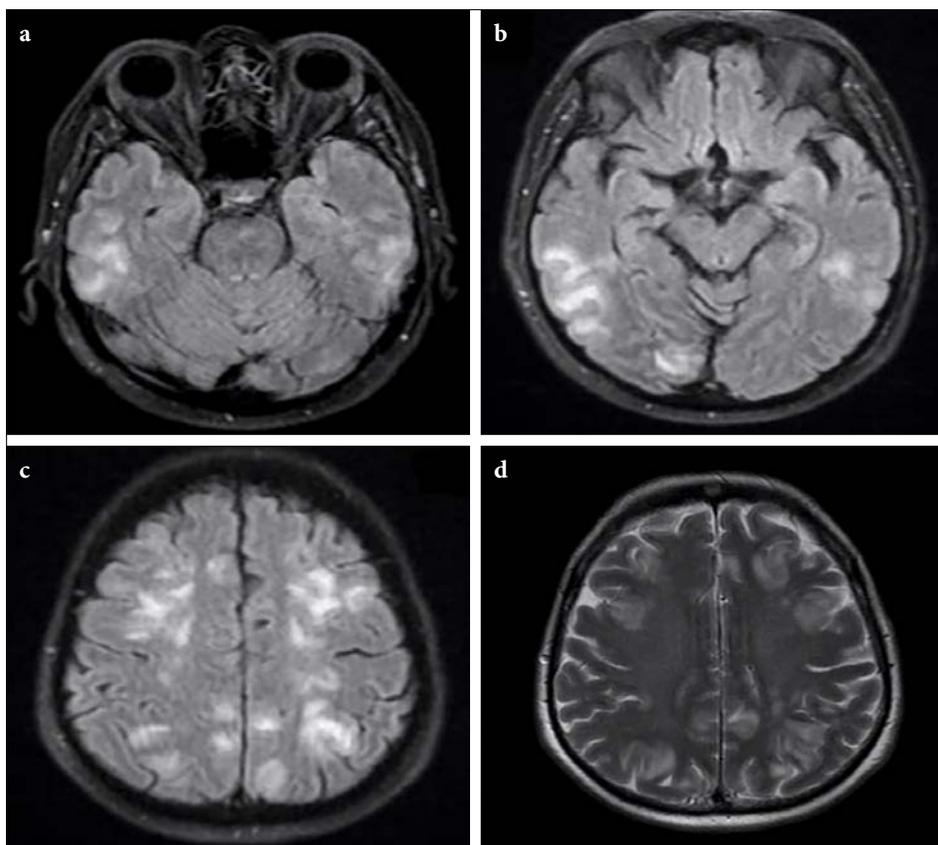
(a-c) Axial Fluid-Attenuated-Inversion-Recovery (FLAIR) magnetic resonance imaging (MRI), widespread changes were observed in the cortical subcortical white matter in the frontal, parietal occipital and temporal regions on the right and left, in the bilateral thalamus, and more prominently in the pons and mesencephalon on the left. (d) Axial T2 MRI image shows cortical subcortical hyperintensity in similar areas.
